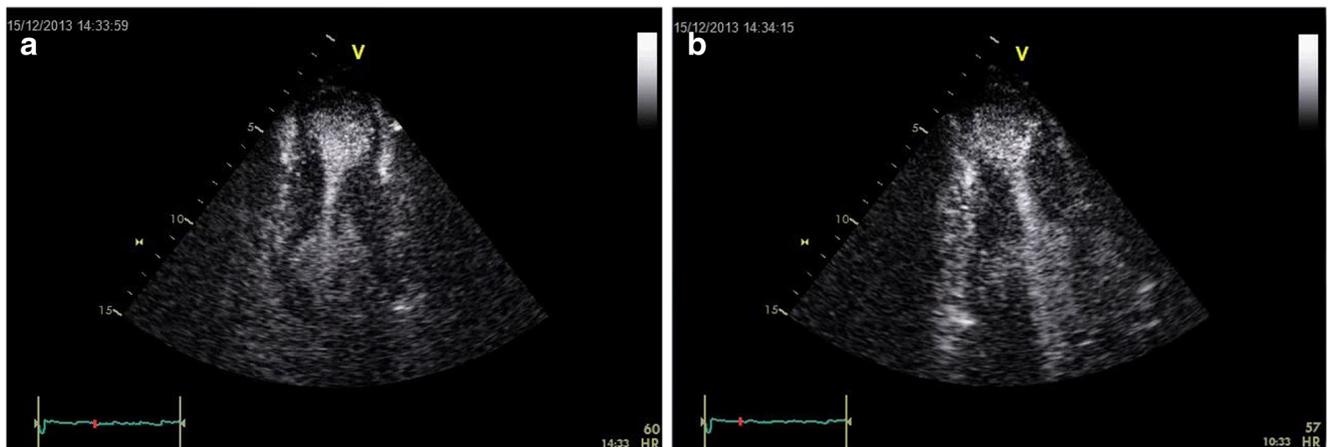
Contrast echocardiography: four-chamber (a) and two-chamber (b) views of midventricular hypertrophy with apical aneurysm and thrombus formation within the aneurysm
